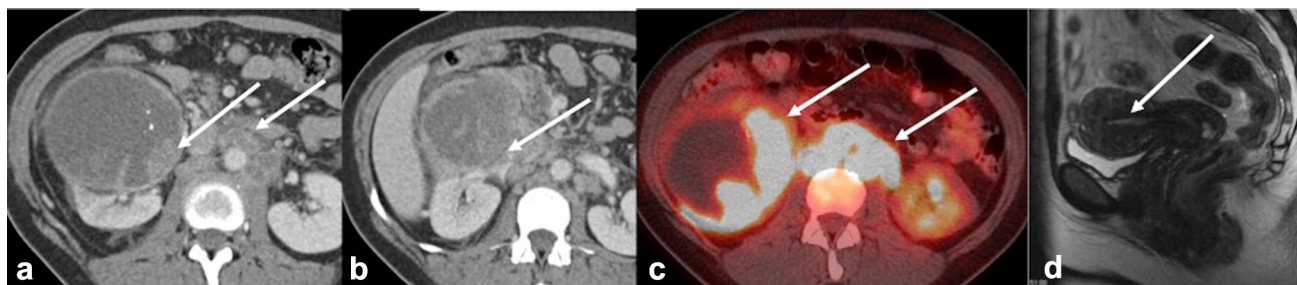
A 44-year-old woman with right flank pain and elevated HCG who was referred for imaging based on clinical concern for gestational trophoblastic disease. a Axial contrast-enhanced CT shows a large heterogeneous right renal mass, large retroperitoneal lymphadenopathy, and b involvement of the IVC. c Fused axial images from FDG-PET/CT show marked FDG-avidity of the tumor
